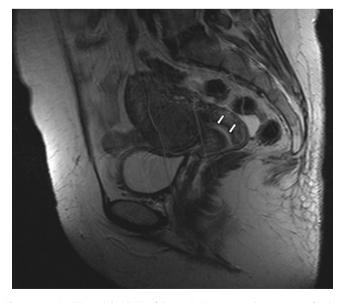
Sagittal T2-weighted MRI of the cervix shows normal appearance of endocervical mucosa (arrows). No tumoral focus is seen.
